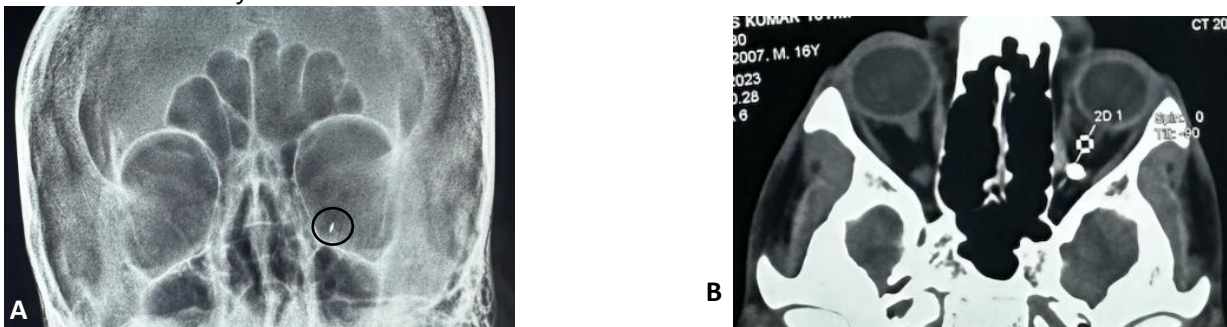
First documentation of metallic orbital foreign body (in black circle) in left orbit (X-ray-Towne's view). Fig.3B.CT scan head and orbit, axial scan showing location of foreign body in medial aspect of intraconal compartment abutting the medial rectus and intraconal part of optic nerve.
